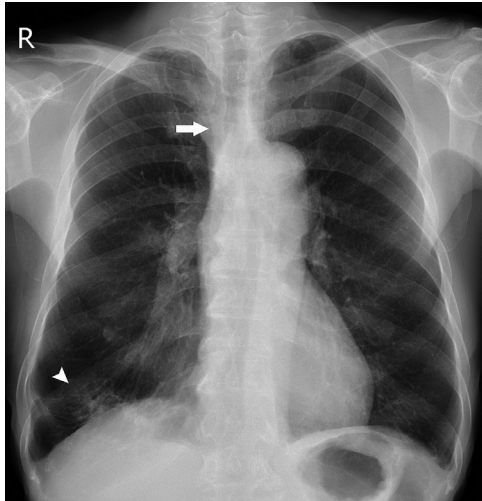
Initial posteroanterior chest radiograph showed slight widening of the right paratracheal stripe (arrow). Focal ill-defined patchy consolidation and linear opacities are noted in right lower lung zone (arrowhead), suggestive of pneumonia.
